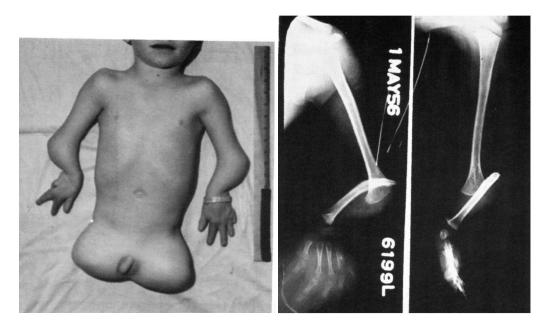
Left, bilateral ulnar hemimelia. The left is intercalary, since there are five digits; the right is terminal because there are only four digits. Patient has complete anonychia with distinctive pulp prints on the dorsum of the fingers. Right, X-rays reveal complete dislocation of the radiohumeraljoints.
